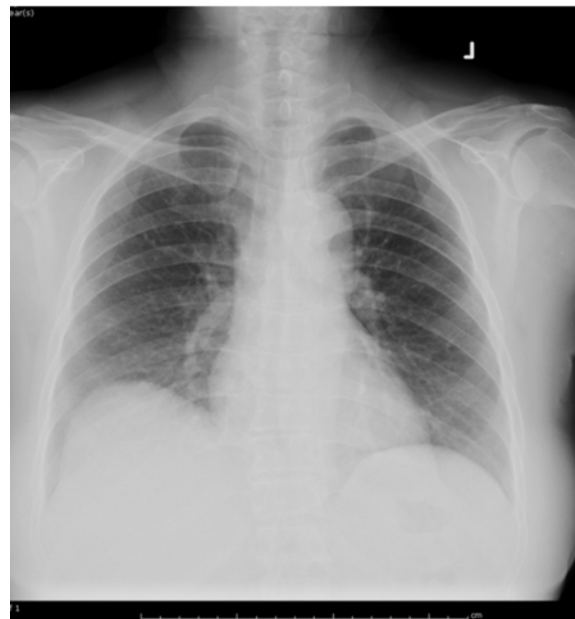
Chest x-ray before TACE
